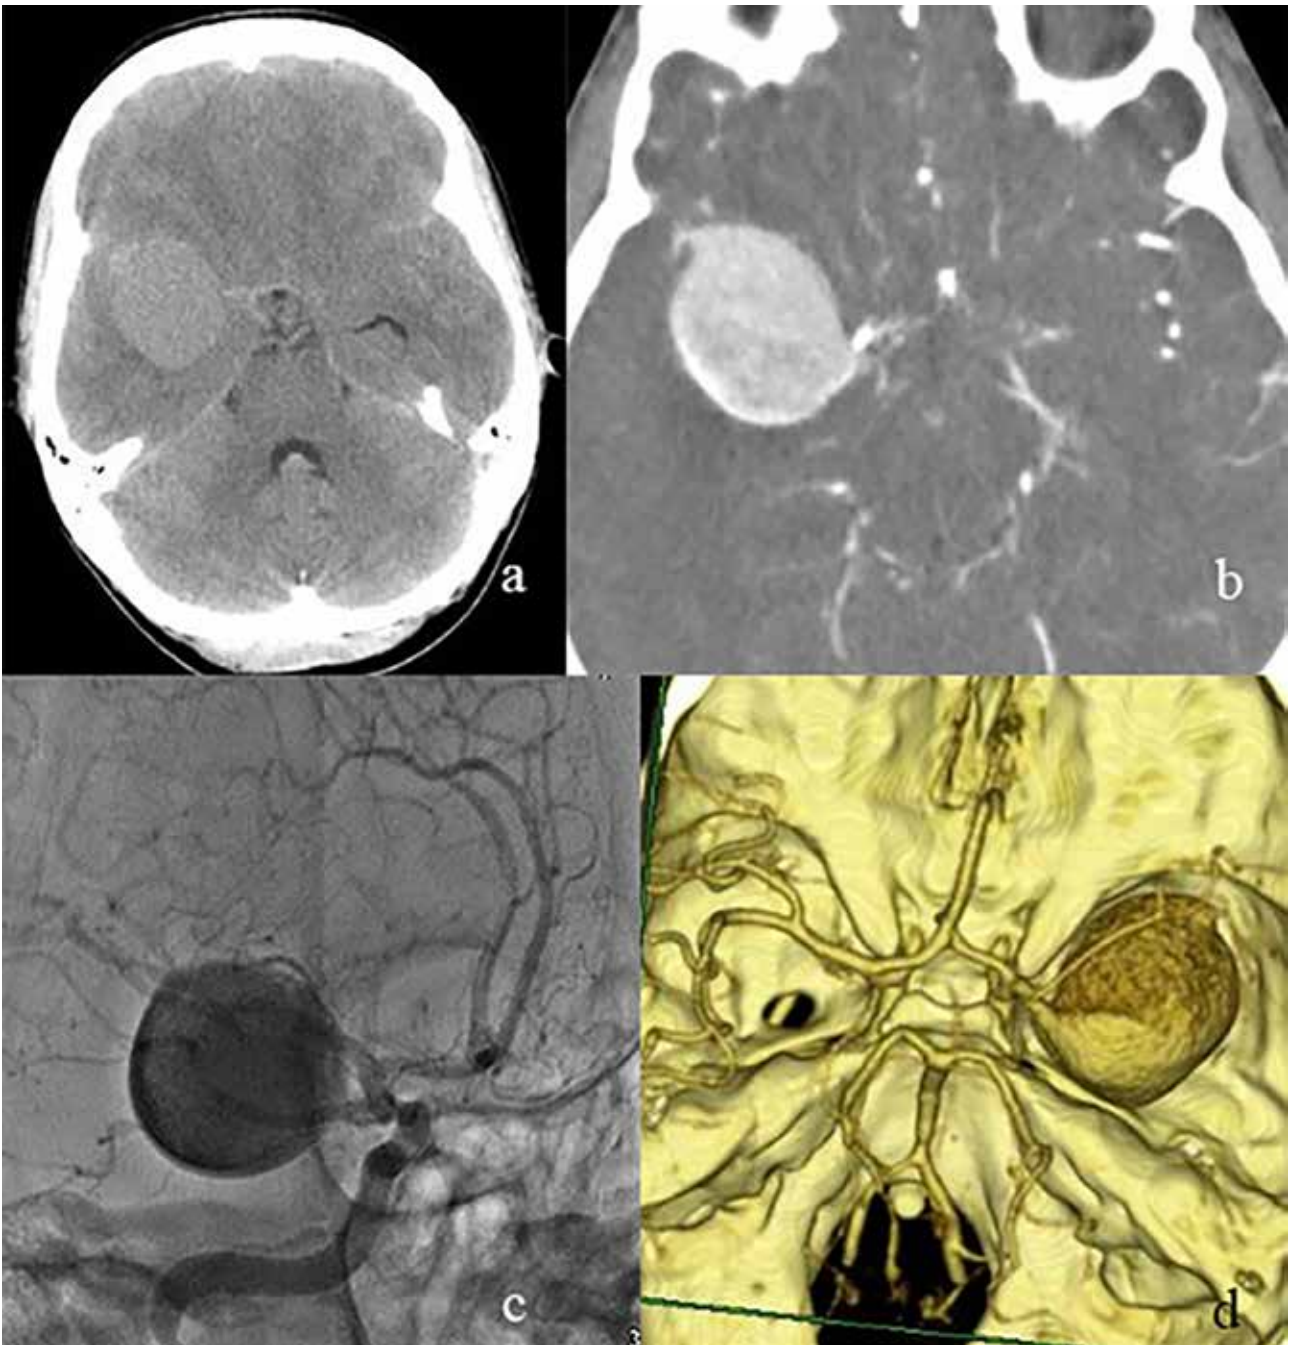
Saccular aneurysm at ACM dex. vessel: a - axial CT; b - CT angiography basic; c - angiography; d - CT angiography 3D reconstruction.
